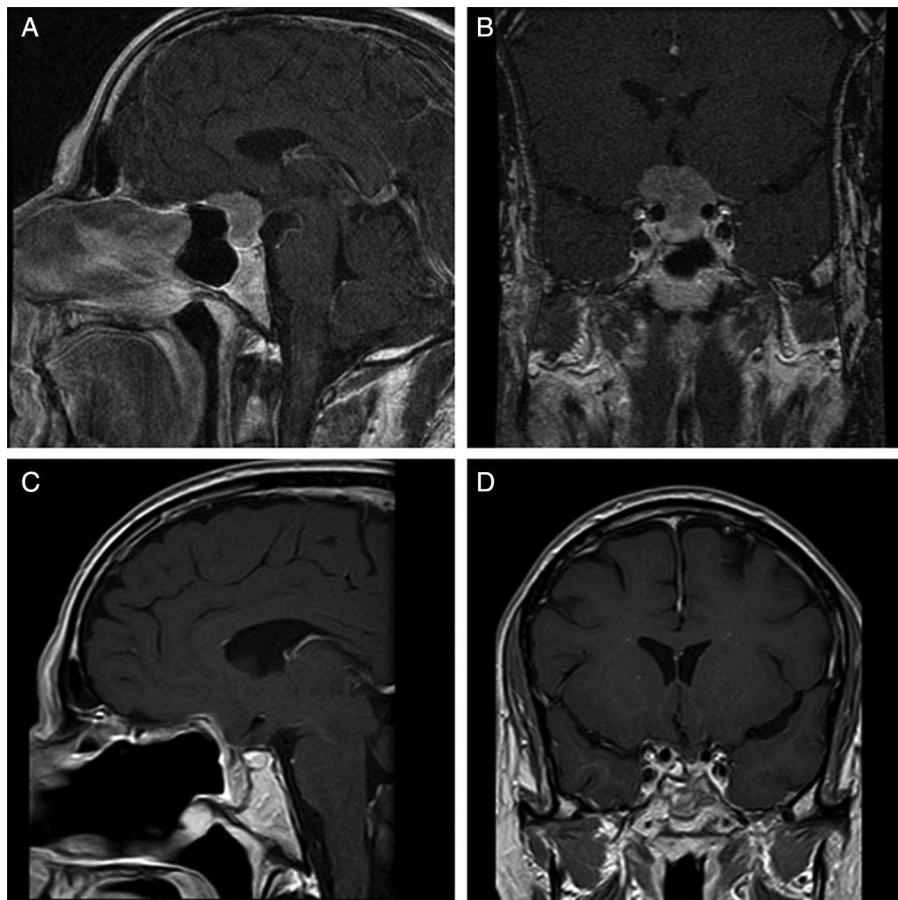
Preoperative magnetic resonance showing an apparently single sellar lesion with suprasellar extension to the tuberculum sellae and planum sphenoidale: (A) sagittal gadolinium enhanced T1-weighted image and (B) coronal gadolinium-enhanced T1-weighted image. Postoperative study with the same sagittal (C) and coronal (D) sequences shows a complete resection and sealing of the skull base with a nasoseptal flap.
